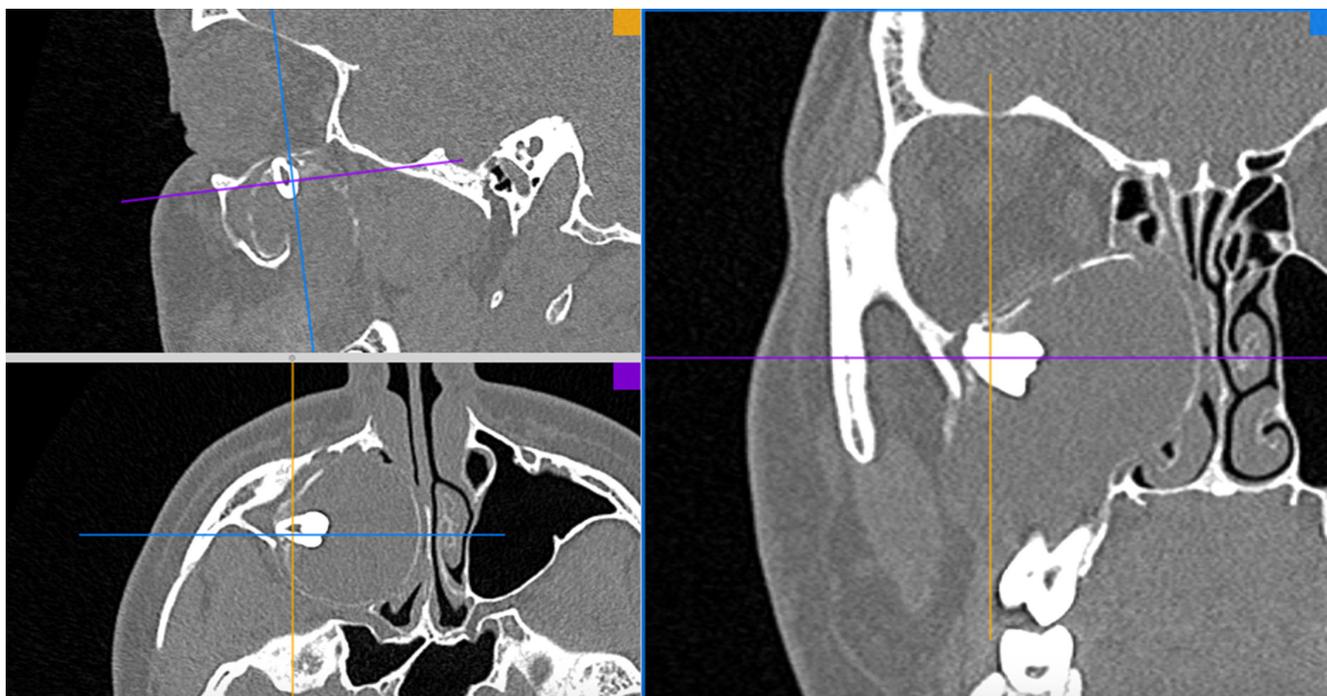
Computed tomography imaging. Three projections show an ectopic tooth in a distorted right maxillary sinus filled with inflammatory masses.
